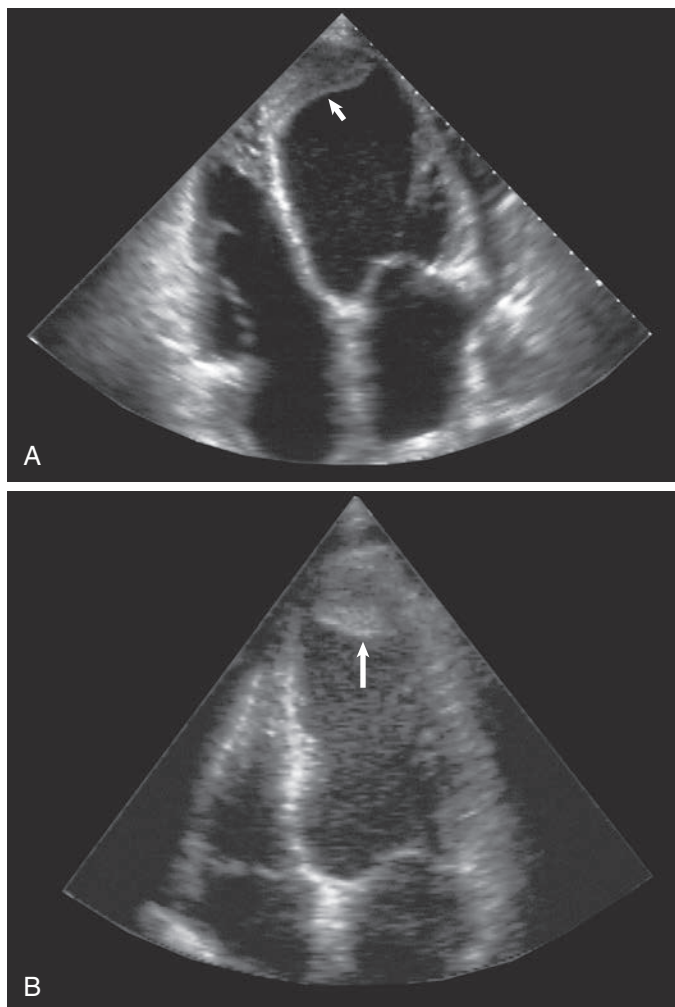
Left ventricular (LV) thrombus. (A and B) LV thrombi in the apical four-chamber view from echocardiograms for two different patients. (A) An organized and nonmobile thrombus is detected in the first patient (arrow). (B) In the second patient, a mobile thrombus (arrow) is seen in a region of akinesia and apical aneurysm. (From Díaz A, Ducharme A, Tardif JC: *Echocardiography in acute coronary syndromes*. In Thérioux P, editor: *Acute coronary syndromes*, Saunders, Philadelphia, 2011.)
